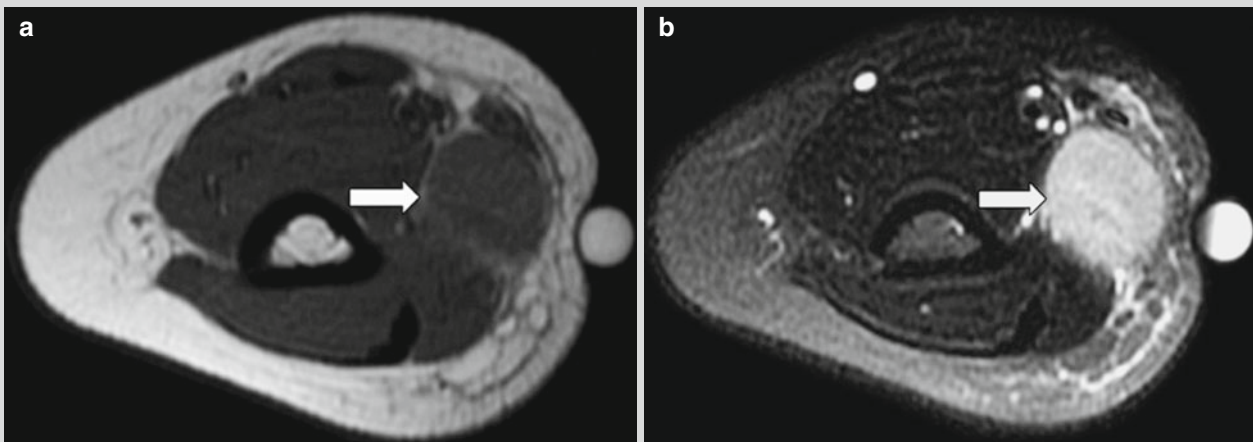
CSD lymphadenitis in the right armpit. (a) MR imaging demonstrates oval nodules in the right armpit, with surrounding edema. T1WI signals are equal (indicated by *arrows*). (b) T2WI fat-suppression sequence demonstrates high signals. (c) After the injection of contrast
